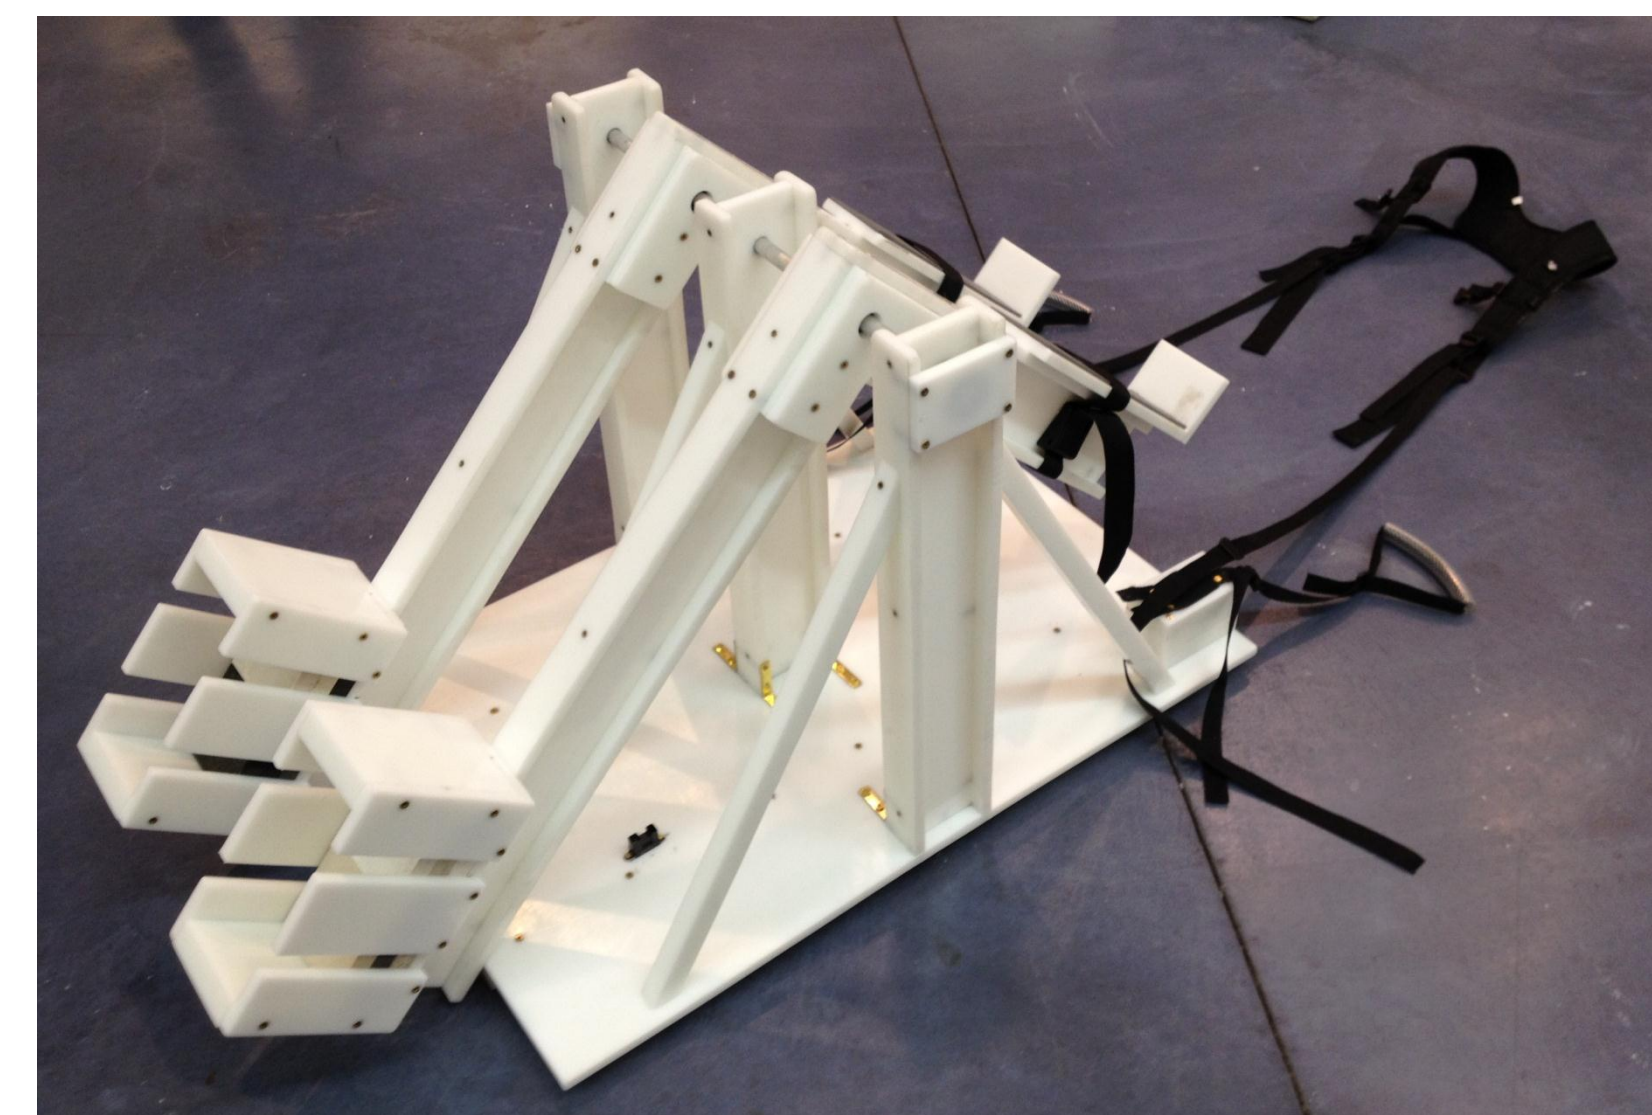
MRI-compatible exercise device - final prototype
